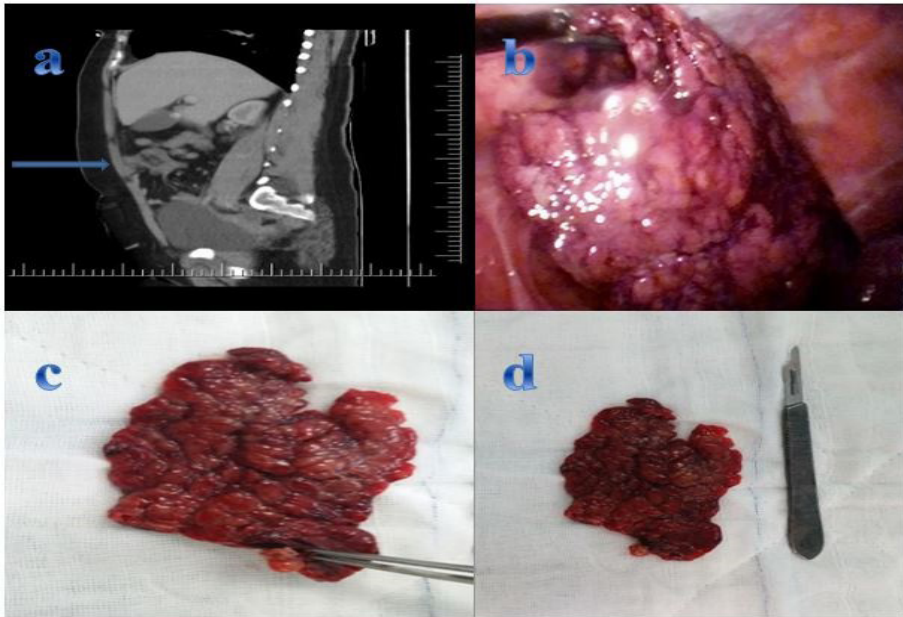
Torsion of the Omentum and Laparoscopic Resection (a: Abdominal computed tomographic image of segmental omental torsion; b: Laparoscopic image of segmental omental torsion; c and d: Resection image of segmental omental torsion)
